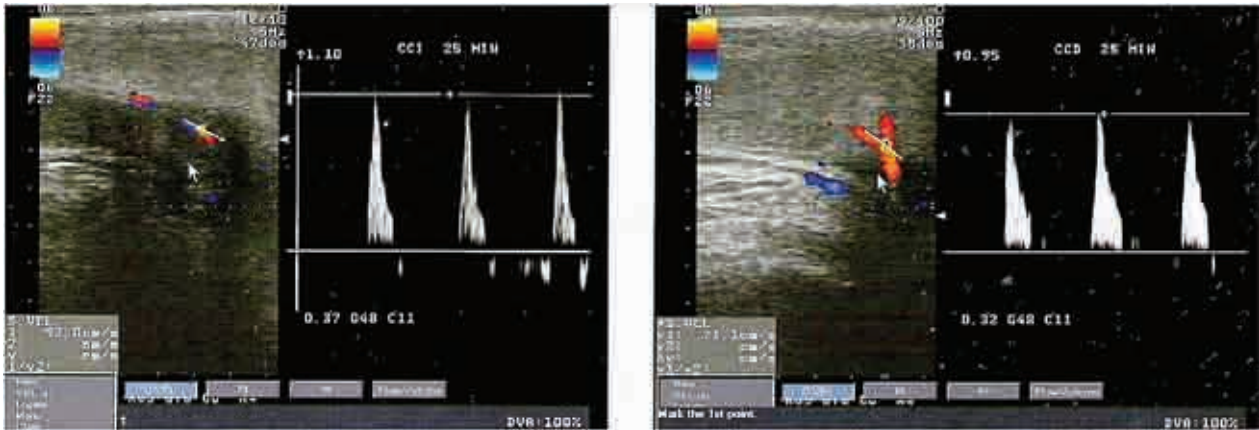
Doppler ultrasound of the penis showing adequate systolic velocities.
